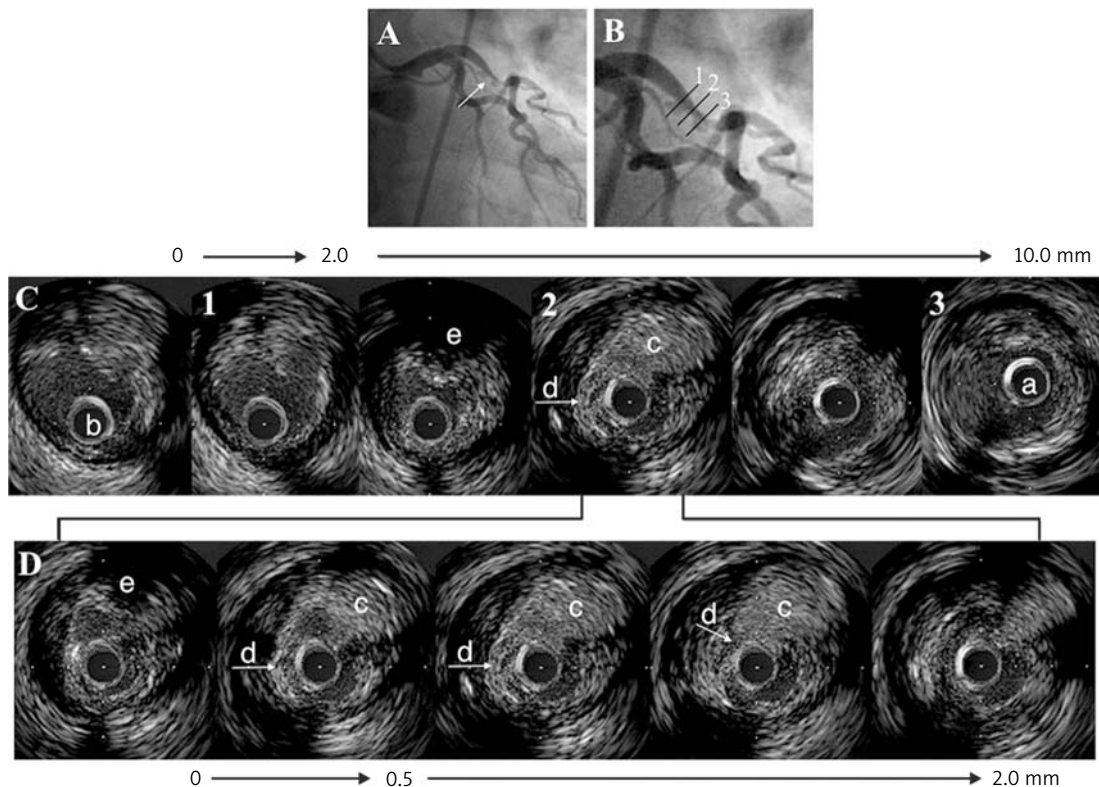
This patient presented with a non-Q myocardial infarction and a complex plaque in the left anterior descending artery (white arrows in Panel A). Two IVUS imaging runs from distal (“a”) to proximal (“b”) are shown; in Panel C the image slices are 2.0mm apart, and in Panel D the slices are 0.5mm apart allowing greater detail to be shown. Note the thrombus that originates in the ruptured plaque cavity (“c”) and that protrudes into where it wraps around the IVUS catheter the lumen (“d”) to encroach on the lumen. In some frames (“e”) the thrombus is associated with attenuation. The lines in Panel B correspond to the IVUS image slices “1” through “3.” When the angiogram is reviewed with the IVUS information in mind, there is a thrombus (“2”) within a ruptured plaque cavity (“1” and “3”) (from Mintz GS. Intracoronary Ultrasound. London, Taylor and Francis Group, 2005)
